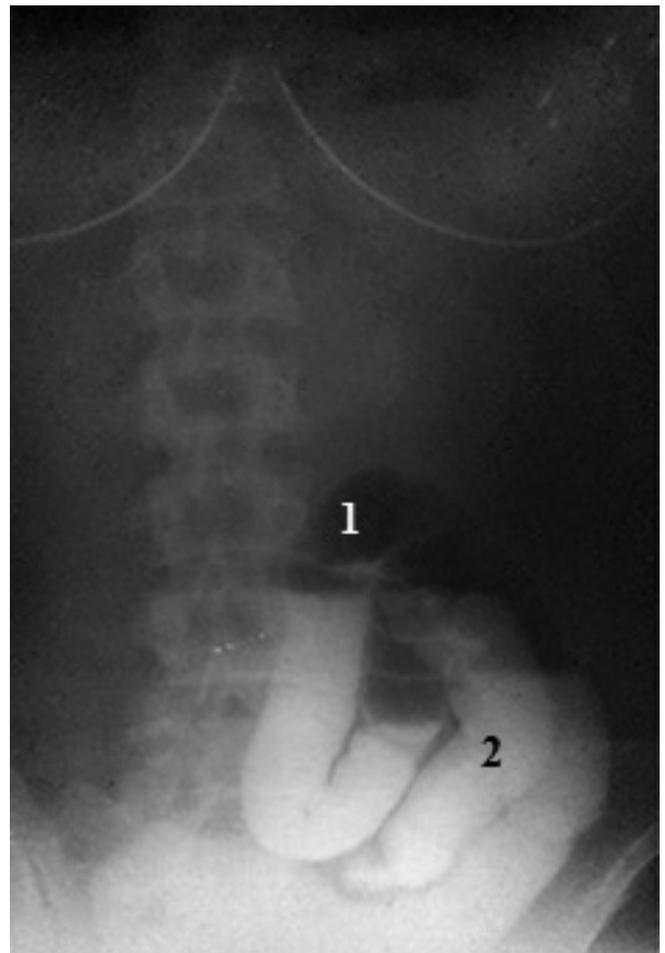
X-ray of the patient B. After 3 hours after contrast giving. Flatus (1) and contrast depot in ileum (2) are determined
